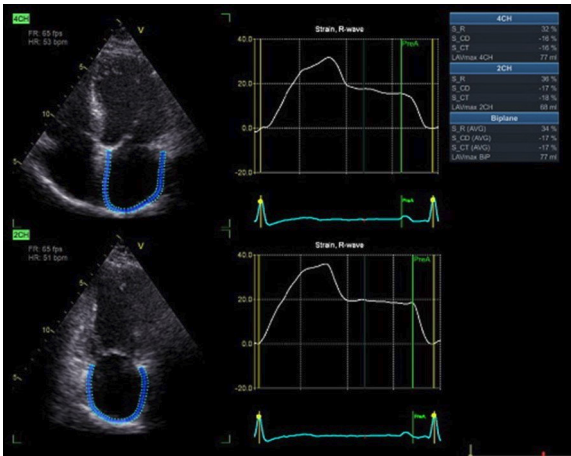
The image represents the analysis of left atrial (LA) strain and the LA maximal volume using specialised software, a two-dimensional speckle-tracking analysis of LA function (AFI LA, EchoPAC 204, GE Vingmed, Horten, Norway). The left panel of the image displays the apical four-chamber and two-chamber views in biplane format. The middle section of the image shows the atrial strain curves, while the right section displays the LA strain and volume calculations. AFI, automated functional imaging.
